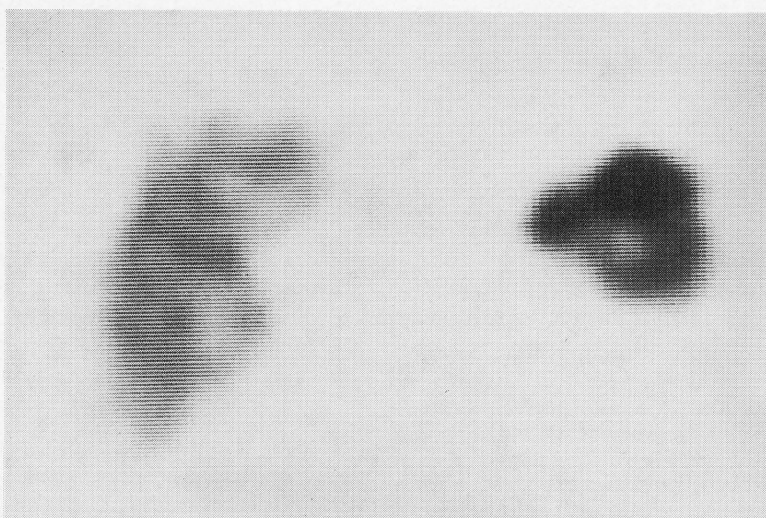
SPECT coronal image also suggests Ga-67 accumulates in the stomach.
